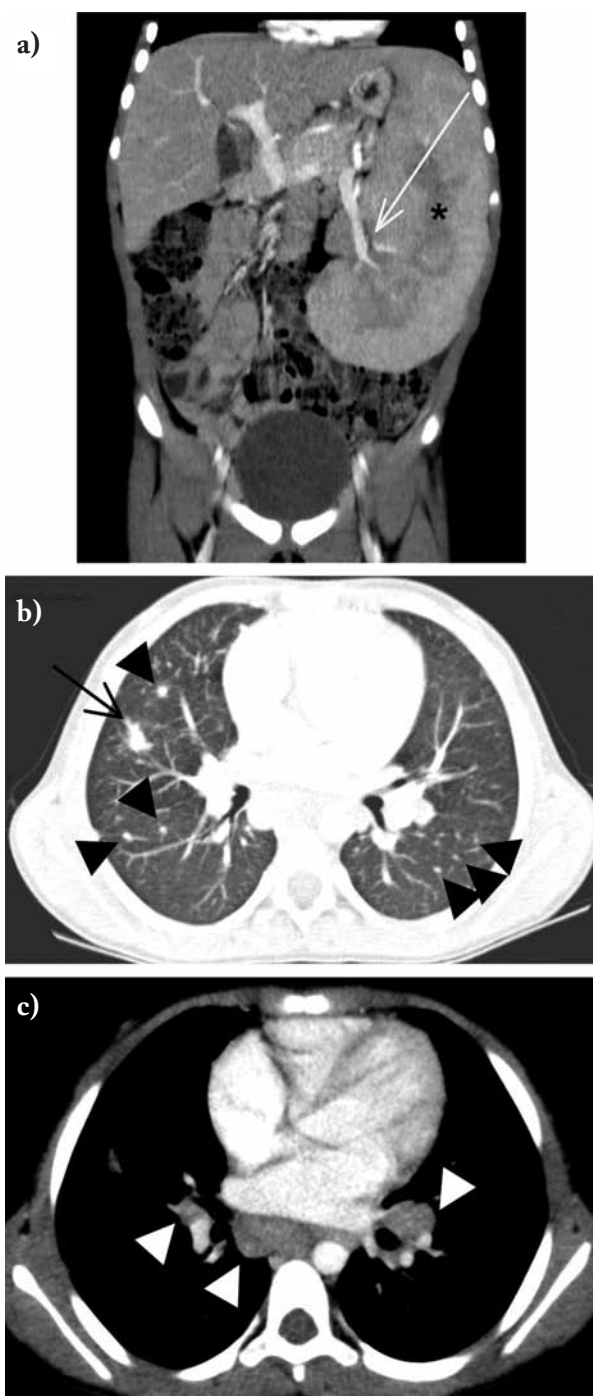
Initial CT scans. (a) Abdominal CT scan showed a massive heterogeneous splenomegaly (*) and a hypodense perivascular infiltration (white arrow). (b) Thoracic CT scan revealed bilateral lung micronodules, predominantly in the left lung (short arrows) and one irregular nodule in the right upper lobe (long arrow), that resulted from the confluence of numerous micronodules. (c) Thoracic CT scan showed bilateral hilar and mediastinal lymph nodes (white arrows).
